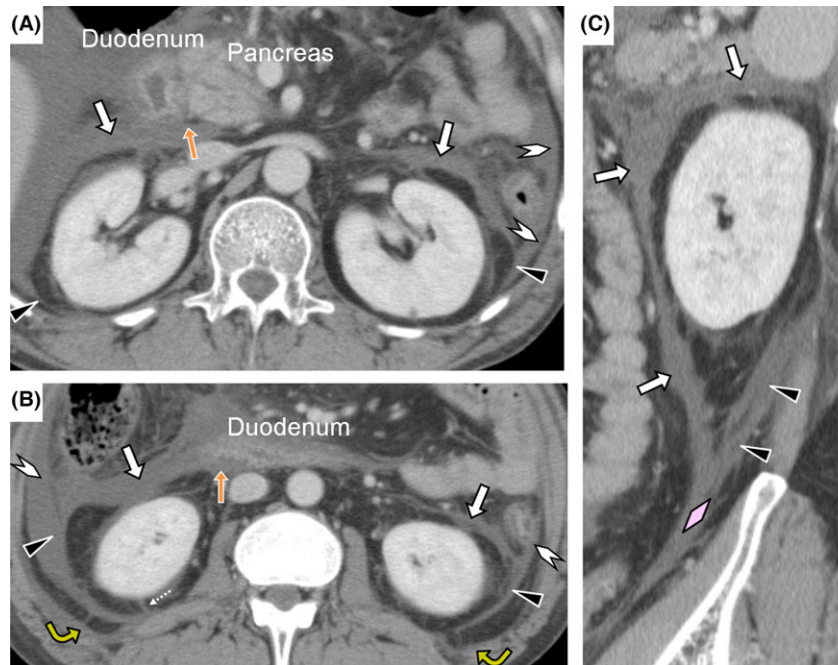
Acute pancreatitis. A, B, Transverse computed tomography images of a 76-year-old man with severe acute pancreatitis. The pancreas head and the duodenum are swollen and fluid collection spreads within the retromesenteric (white thick arrows), lateroconal (white arrowheads), and retrorenal (black triangles) planes and forms checkmark signs (gold curved arrows) (grade IV). Fluid collection in the retromesenteric plane elevates the duodenum (orange arrows). C, Reconstructed sagittal computed tomography image in the same patient. Note that the retromesenteric (white thick arrows) and retrorenal (black arrows) planes unite to form the combined interfascial plane (pink rhombus). He recovered 15 days after admission with intensive care.
